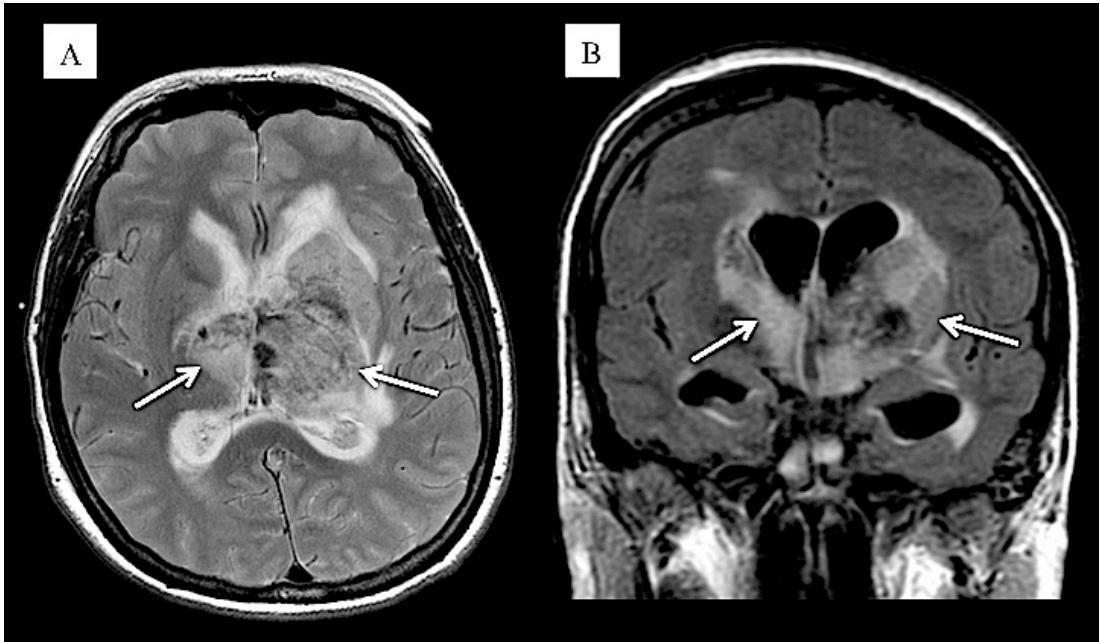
Brain MRI (A) axial T2W (B) coronal T2 FLAIR sequence showing heterogenous mixed signal intensity and cytotoxic oedema within both thalami and left basal ganglia (arrows) with associated mass effect and obstructive hydrocephalus.
